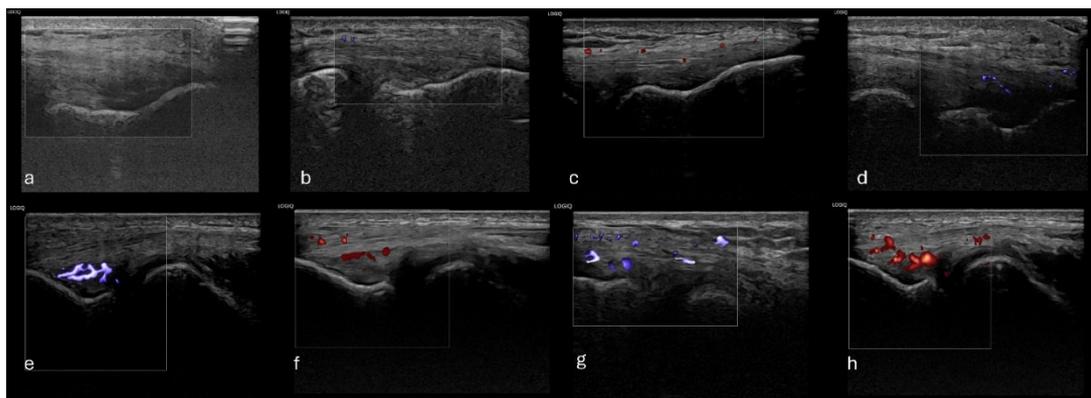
Representative Power Doppler (PD) and microvascular imaging (MVI) images demonstrating the semi-quantitative vascularity grading system of the common extensor tendon. Red color signals indicate Power Doppler, and blue color signals indicate microvascular imaging. (a) Grade 0; (b–c) Grade 1; (d–e–f) Grade 2; (g–h) Grade 3.
